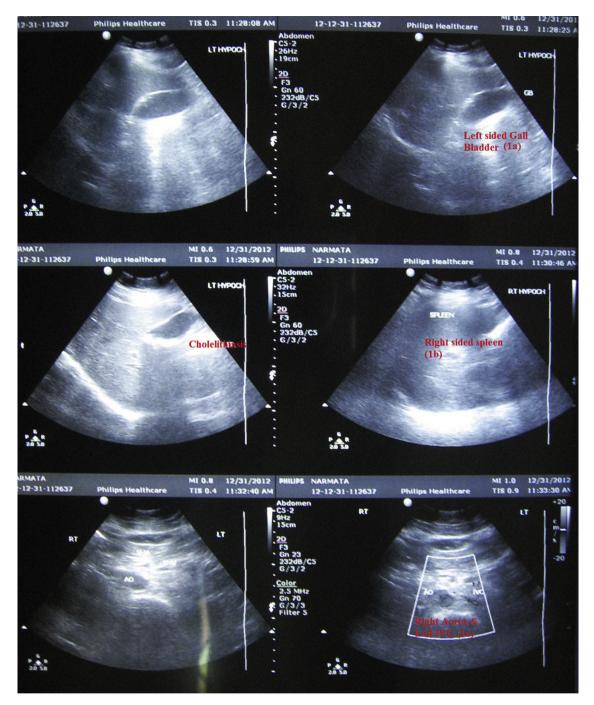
Ultrasonography abdomen-left sided liver & gall bladder (a), right sided spleen (b), left sided IVC and right sided aorta (c).
